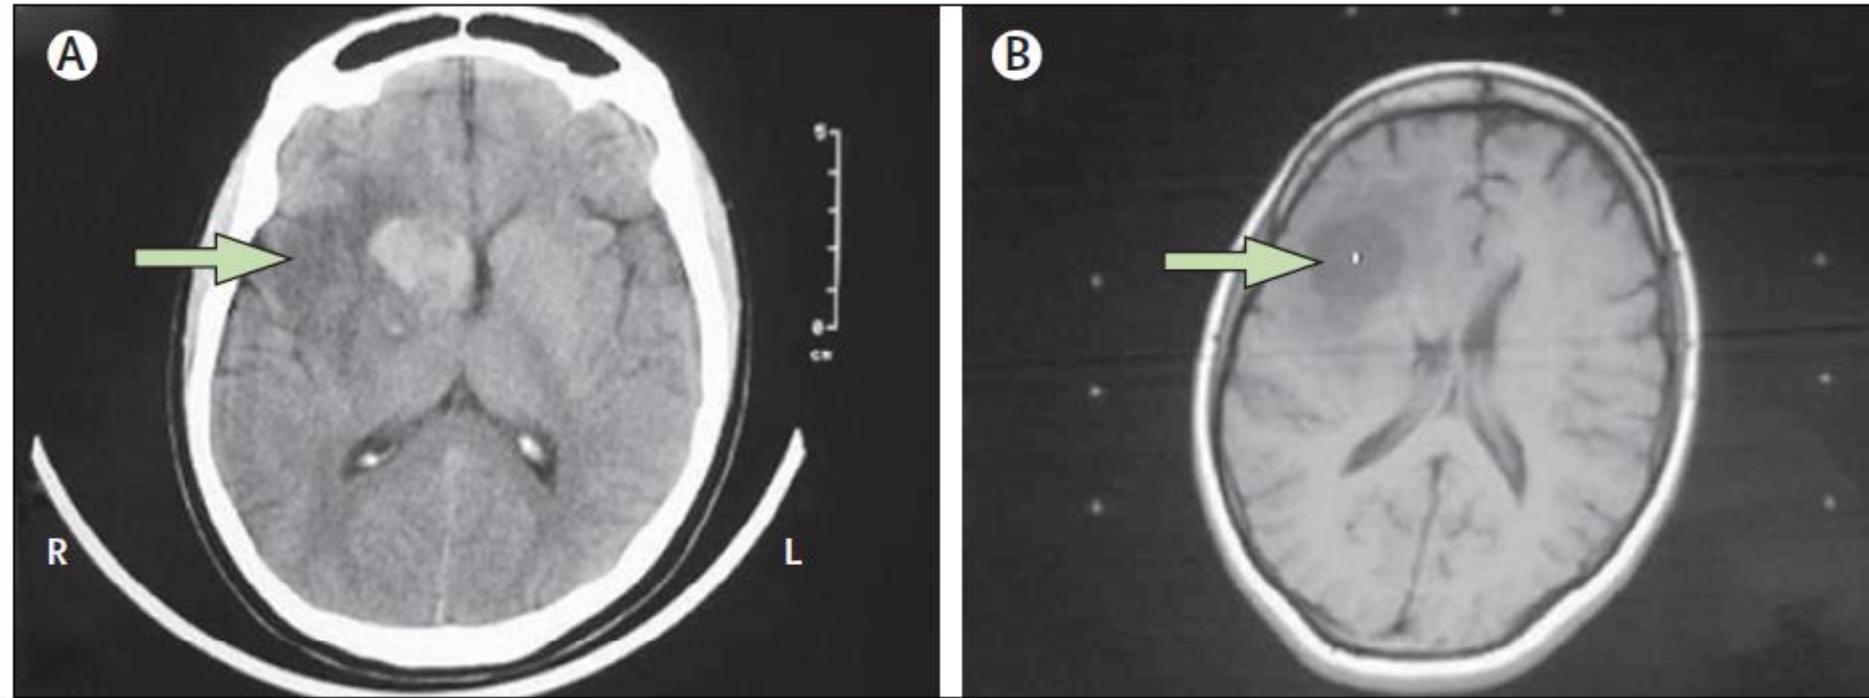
CT scans of the patient's head
